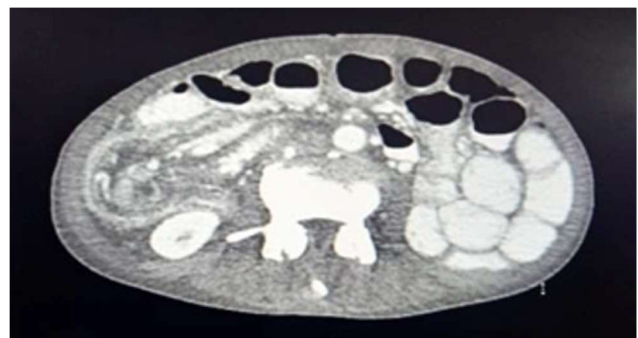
CT abdomen shows ileocaecal intussusception with bowel obstruction
